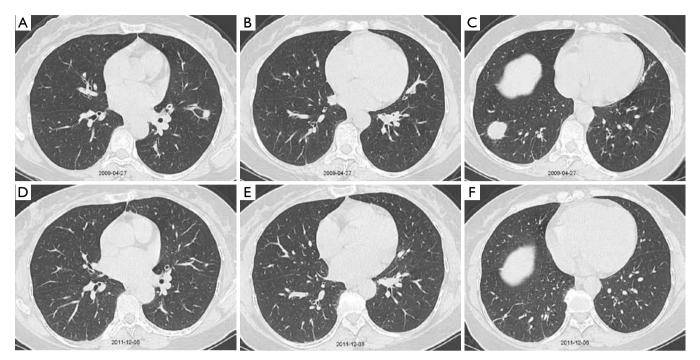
Suspected lung cancer in a 57-year-old female with bilateral multiple lung nodules revealed by CT scanning. Nodules in the lower right lung were diagnosed as OP by CT-guided lung biopsy. The patient voluntarily refused treatment. Follow-up at 32 months revealed that nodules were absorbed, confirming BOOP. Initial chest CT scans showed (A) nodules in the left upper lung with vessel convergence signs; (B) a nodule in the middle lobe of right lung adjacent to the cardiac border; (C) a 2.5 cm nodule in the right lower lung with sentus and strip shadow in the upper lobe of left lung. During follow-up, chest CT scans showed (D) left upper lobe nodule (see in A) was absorbed; (E) the nodule adjacent to the cardiac border (seen in B) was absorbed; and (F) the nodule in the right lower lung and the strip shadow in the left lung were absorbed, with the only remaining strip shadows in the right lower lung. OP, organizing pneumonia.
